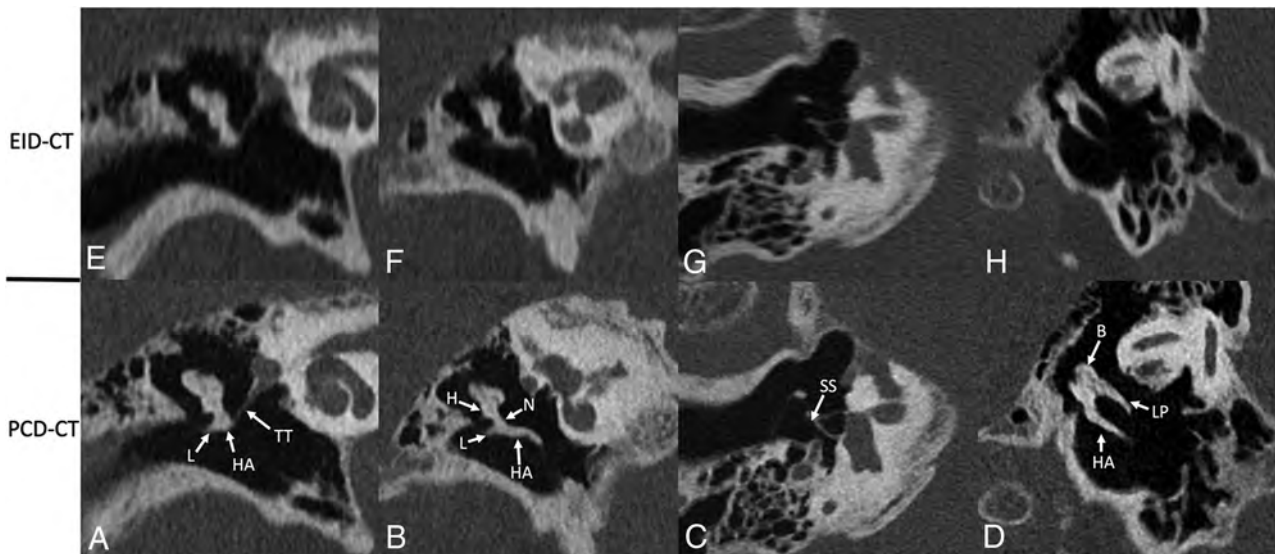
Ossicular anatomy, shown on conventional EID-CT (*upper row*) and PCD-CT (*lower row*). Reformatted images along the plane of the tensor tympani (*A and E*) demonstrate the tensor tympani (TT) extending to the upper handle of the malleus (HA); the lateral process (L) of the malleus is also clearly visible. An image reformatted along the long plane of the malleus (*B and F*) shows its handle (HA), lateral process (L), neck (N), and head (H). An image reformatted along the length of the stapes (*C and G*) clearly demonstrates the suprastructure (SS) and both crura. A “molar tooth” reformatted image (*D and H*) shows the HA of the malleus, as well as the body (B) and long process (LP) of the incus. These additional reformatted images were generated by a nonreviewer radiologist to demonstrate certain anatomic features but were not used by the readers to score image quality.
